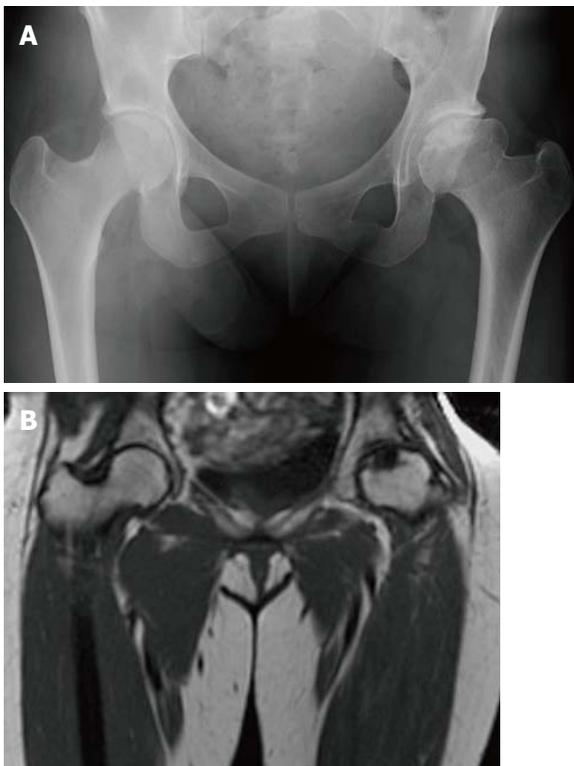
Osteonecrosis. Frontal radiograph of the pelvis (A) shows avascular necrosis of the left femoral head. The femoral head has a flattened contour with sclerosis in the subcapsular areas. Note that the joint space is maintained. Coronal T1 WI (B) in the same patient again demonstrated an abnormal shape of the left femoral head with flattening superiorly. In the same area there is a focus of low SI indicating the devascularized bone.
